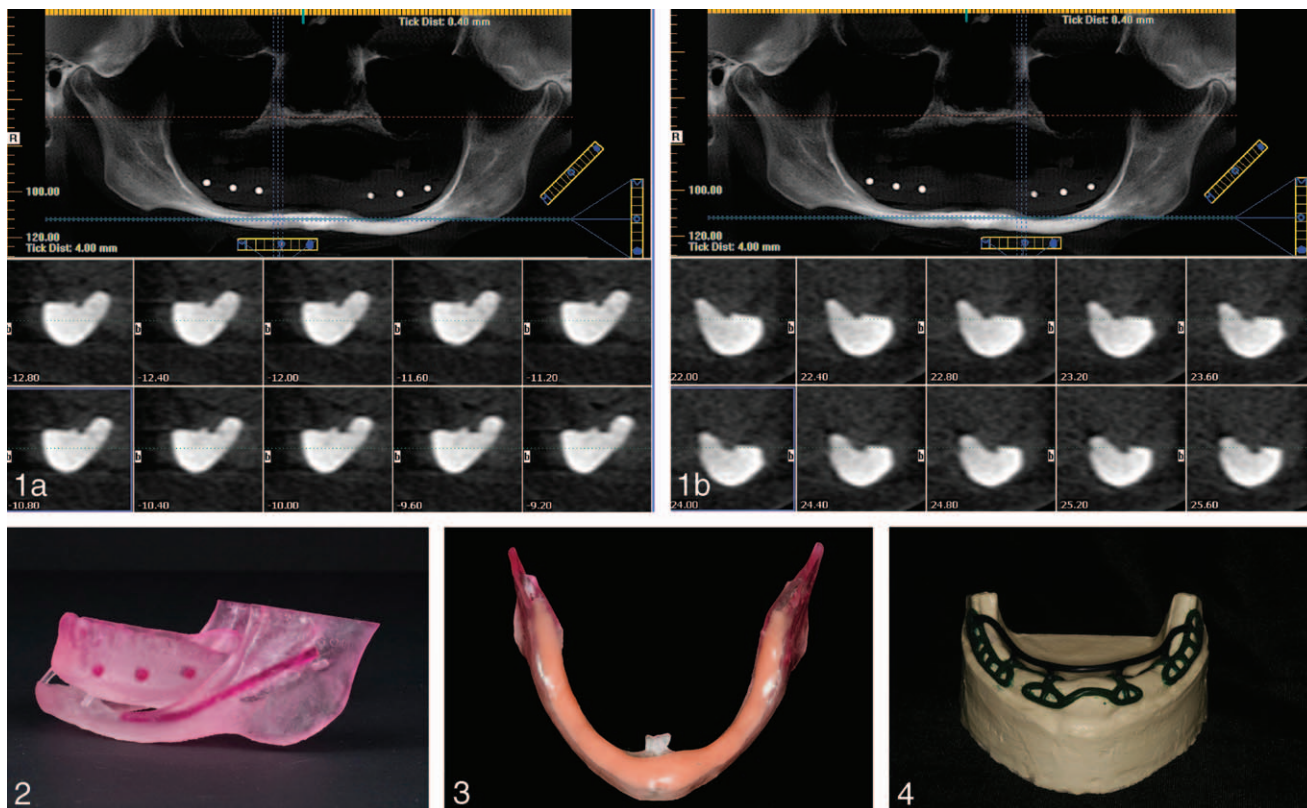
(a) pre-operative CBCT right mandible. (b) pre-operative CBCT left mandible. FIGURE 2. Stereolithographic model of the patient's mandible and complete denture. FIGURE 3. Build-up of the mandibular anatomy to the desired alveolar dimension. FIGURE 4. Refractory stone model with the subperiosteal implant created in wax.
